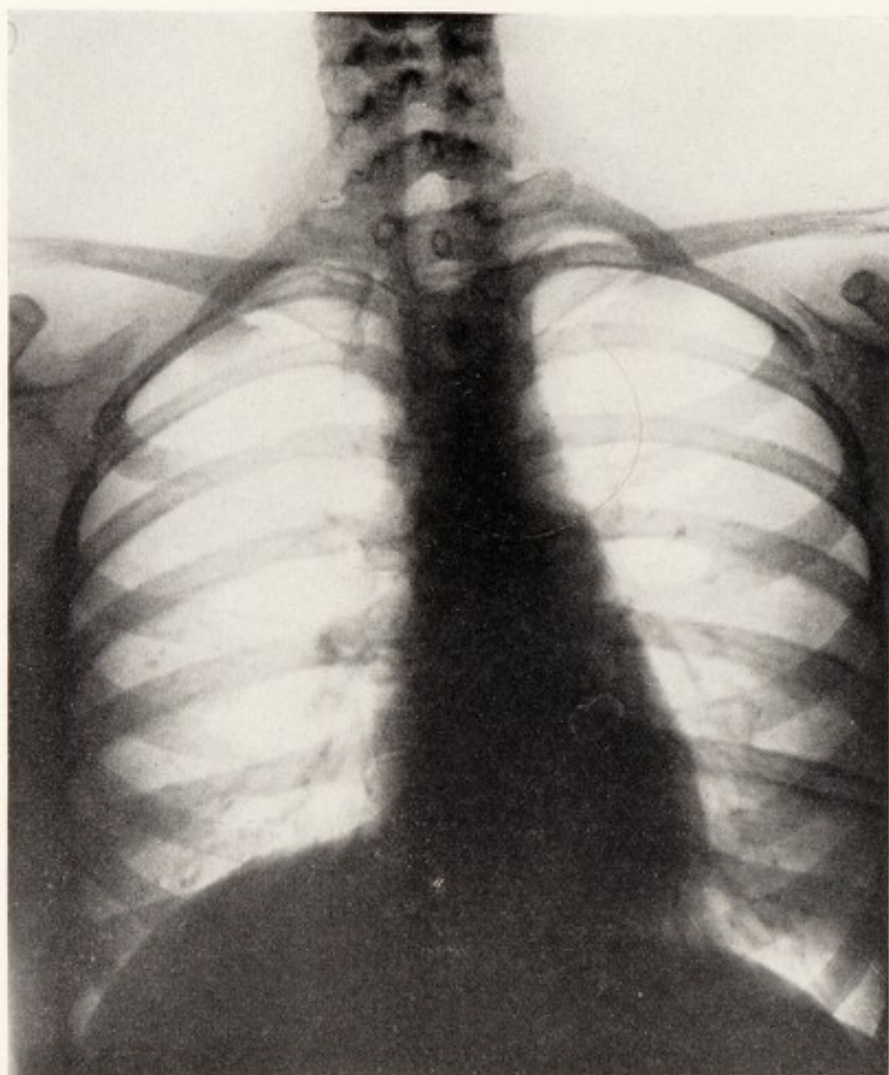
Radiograph in the same case as in Fig. 86 taken four months after the application of radiation therapy. The tumor completely disappeared following a therapeutic test. The rapidity of its disappearance was the basis for the diagnosis of a thymic tumor.
